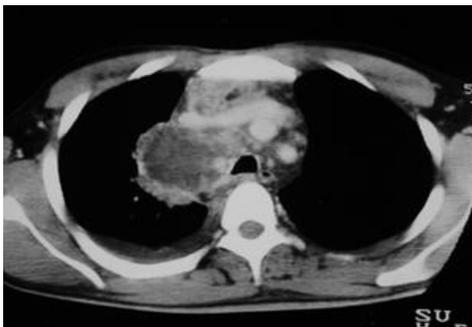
showing HRCT axial image of a large necrotic node in right paratracheal region, findings that are consistent with lymphadenopathy and are typical in paediatric patients.
